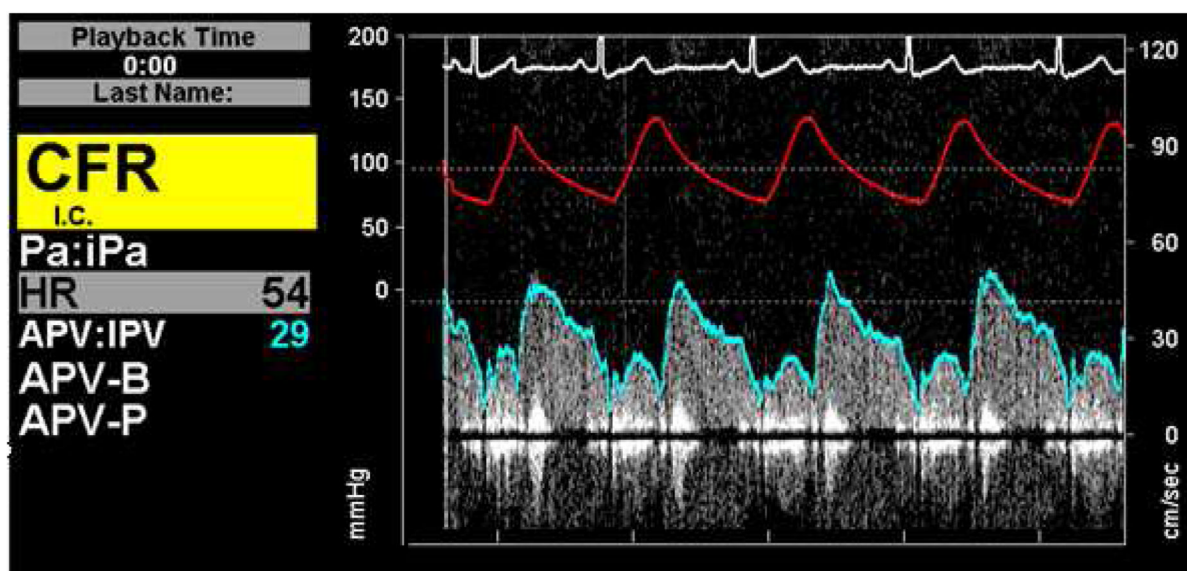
Doppler flow wire in coronary artery measures changes in coronary blood flow and peak velocity in response to Acetylcholine (A: Baseline, B: following injection of 10^{-4} Ach injection demonstrating constriction of the coronary arteries). Arrow indicates tip of the Doppler flow wire positioned at mid-left anterior descending artery.
